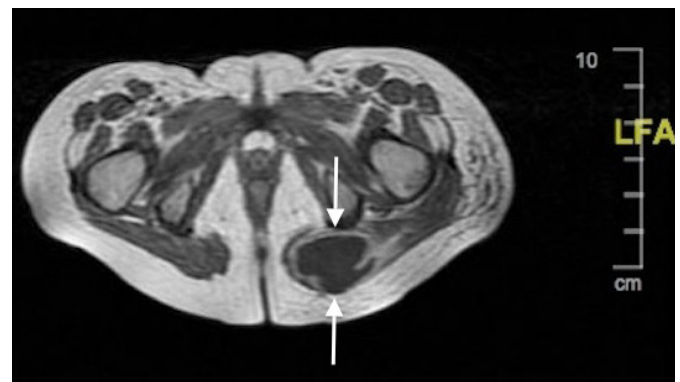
An abscess formation were determined as 24*37*45mm, and it was lied down posterior to inferior of gluteus maximus muscle by MRI.
